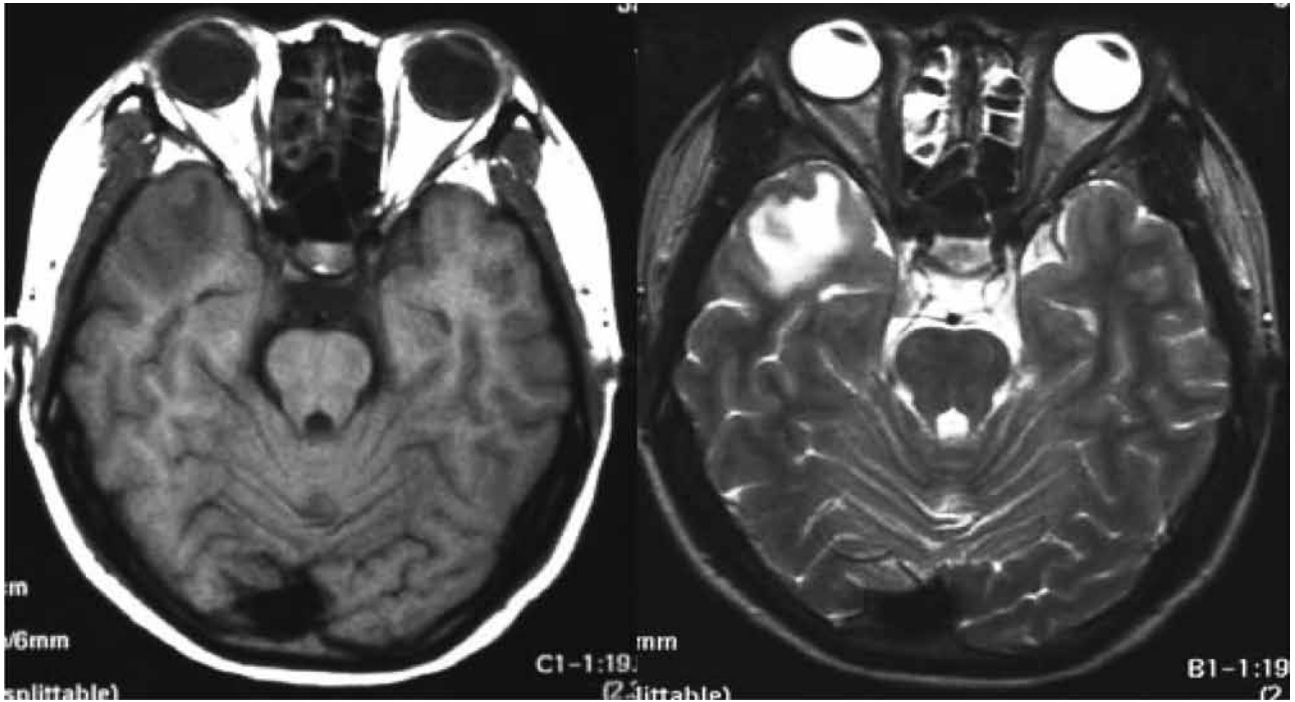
Brain magnetic resonance imaging showed abnormal low T1WI and high T2WI signal intensity mass at right anterior-inferior temporal lobes that measured about 3×3 cm.
